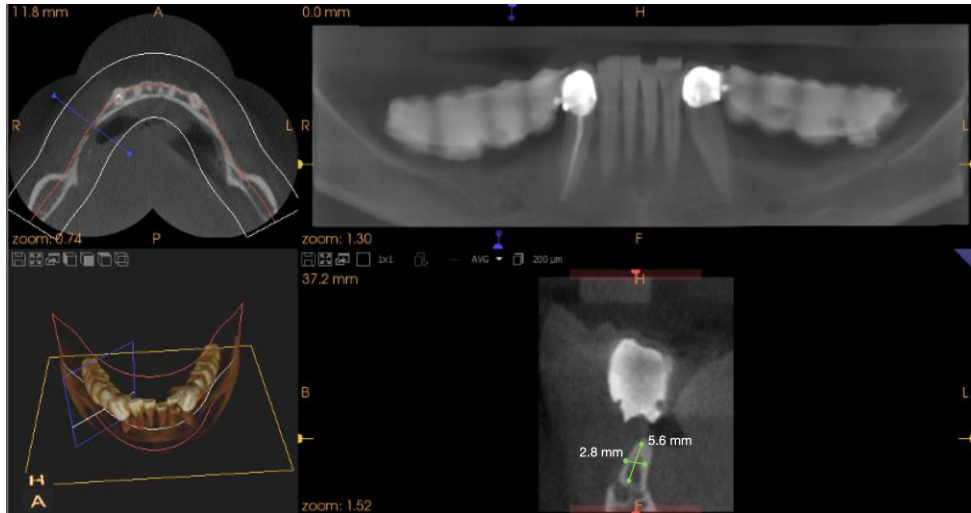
Preoperative CBCT showing the mandibular deficiency
